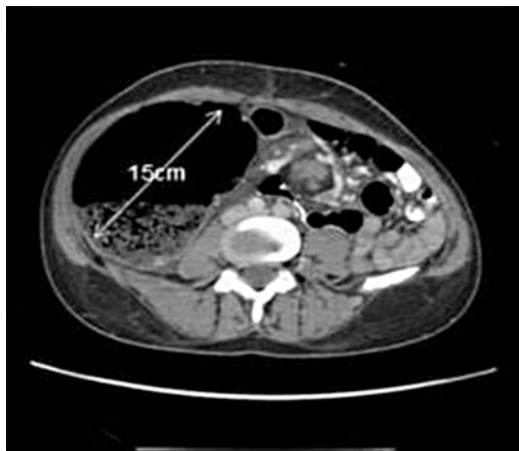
CT scan with 15-cm cecum. © Dale Dangleben, MD
